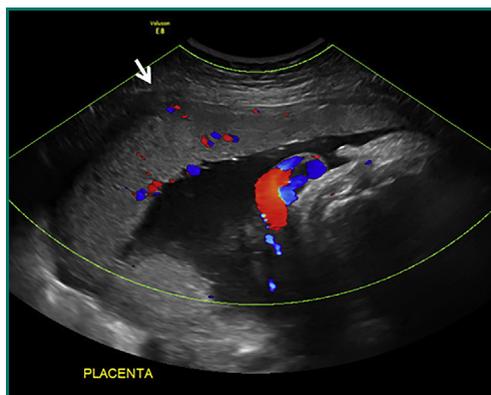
Focal placenta accreta could not be excluded (arrow) by third trimester ultrasound.
